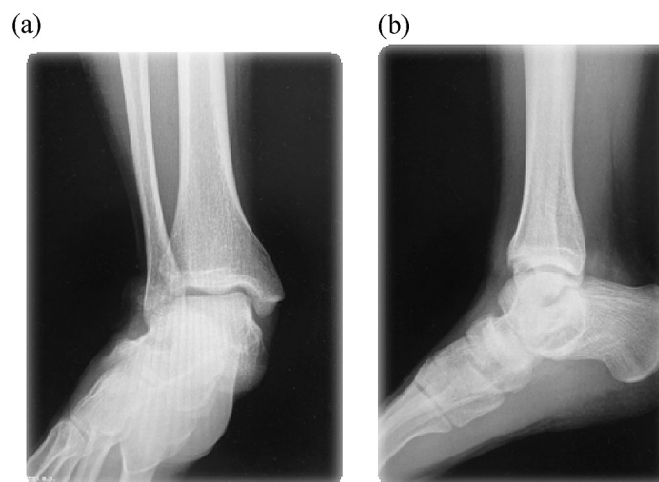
Antero-posterior (a) and lateral (b) ankle radiographs.
